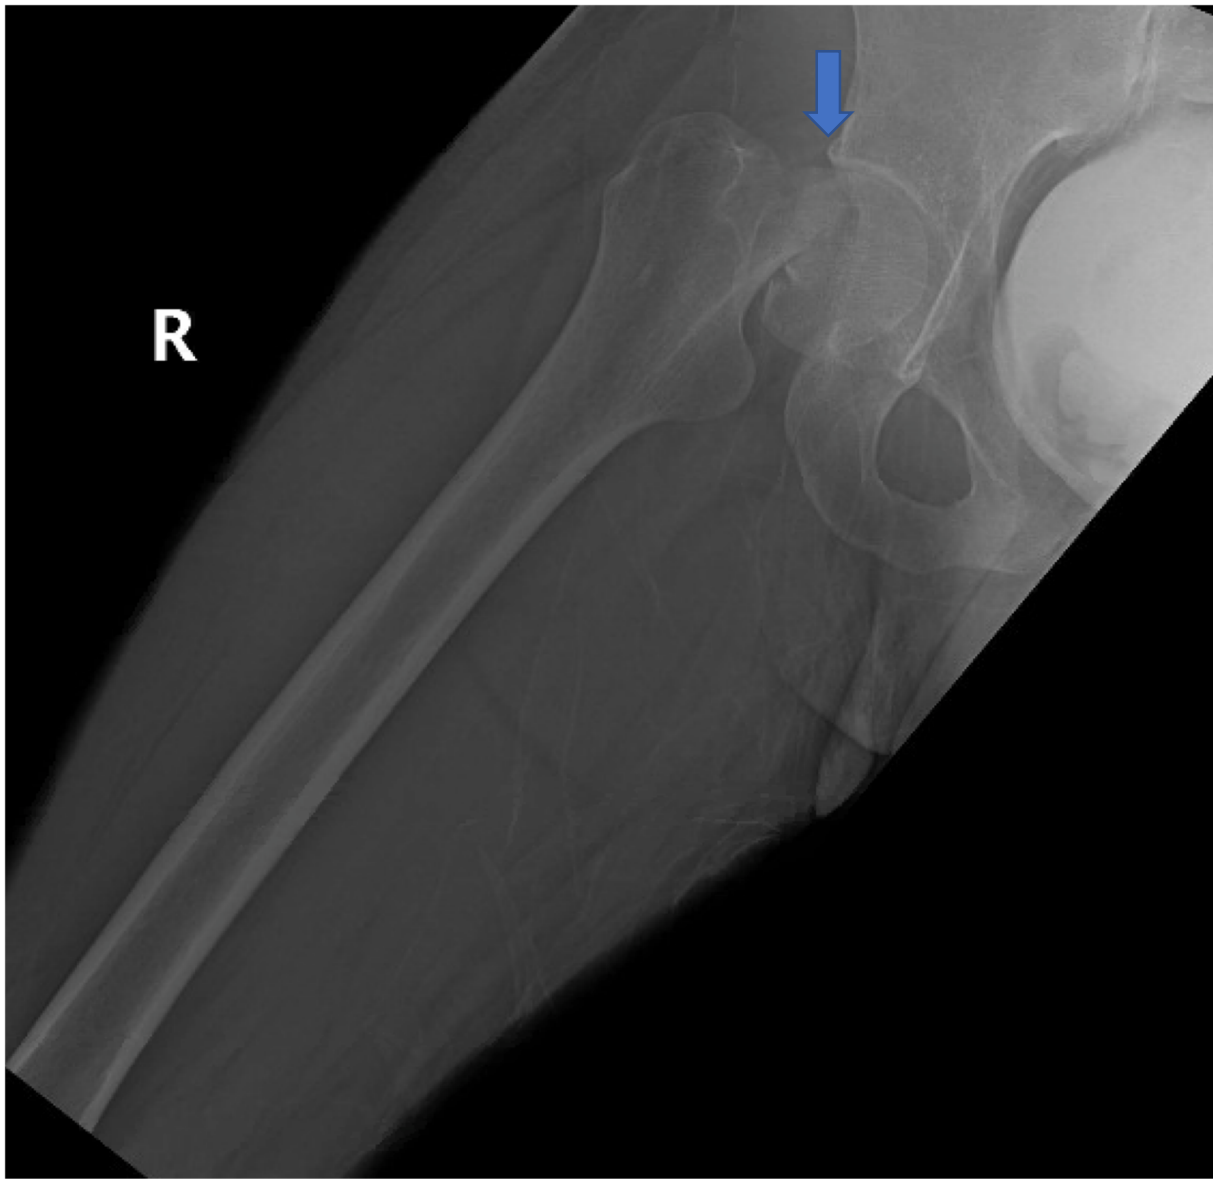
Right femur X-Ray demonstrating the right femoral neck fracture. The arrow is marking the fracture.
